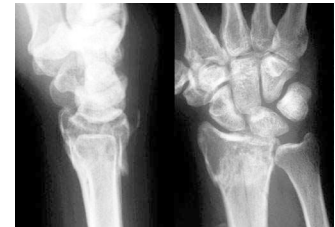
Post-operatively lateral and PA radiographs for case 2.
